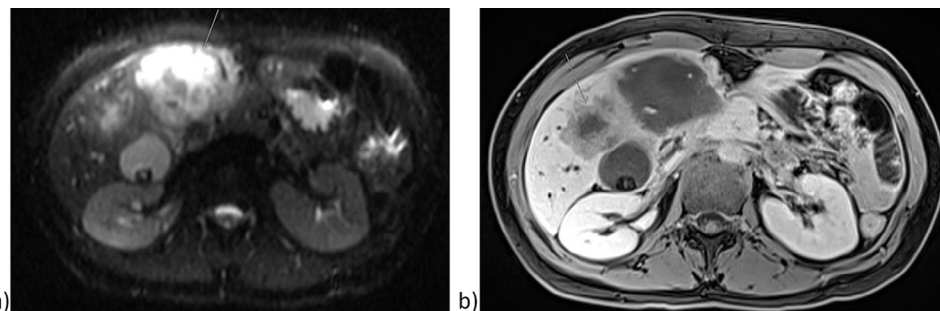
MRI: (A) Axial diffusion-weighted image demonstrates restricted diffusion within the periphery of one of the hepatic lesions (arrow). There is cholelithiasis within a distended gallbladder neck. (B) Axial T1-weighted contrast enhanced image (5-minute delay) demonstrates hepatic lesions with peripheral enhancement and central hypointensity (arrow).
